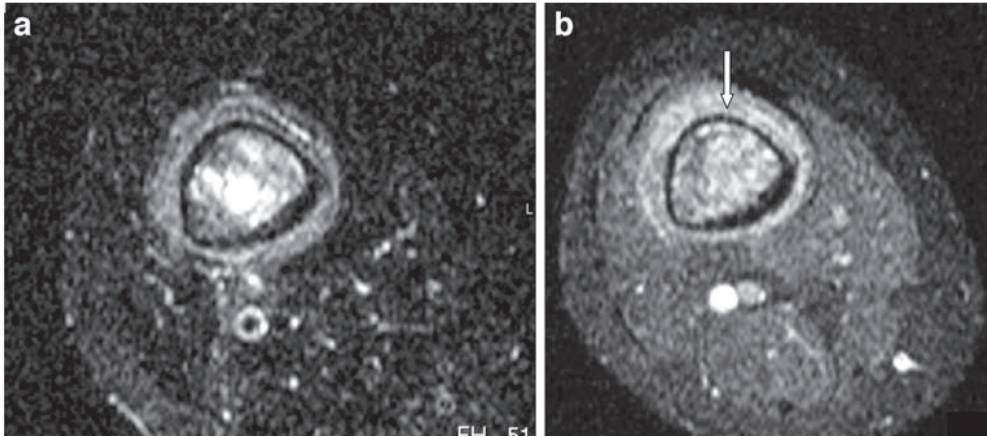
A 32-year-old female patient with primary non-Hodgkin's lymphoma of the distal femur diaphysis. Axial T2-weighted fat-suppressed turbo-spin echo (TSE) (TR/TE 3799/80 ms) image (a) and axial T1-weighted contrast-enhanced fat-suppressed TSE (TR/TE 500/15 ms) image (b). Heterogeneous high SI (a) of intraosseous component and limited circumferential soft-tissue cuff. Heterogeneous enhancement. Permeated cortical bone with linear intracortical, increased SI, particularly seen on Gd-enhanced images (b, arrow)
